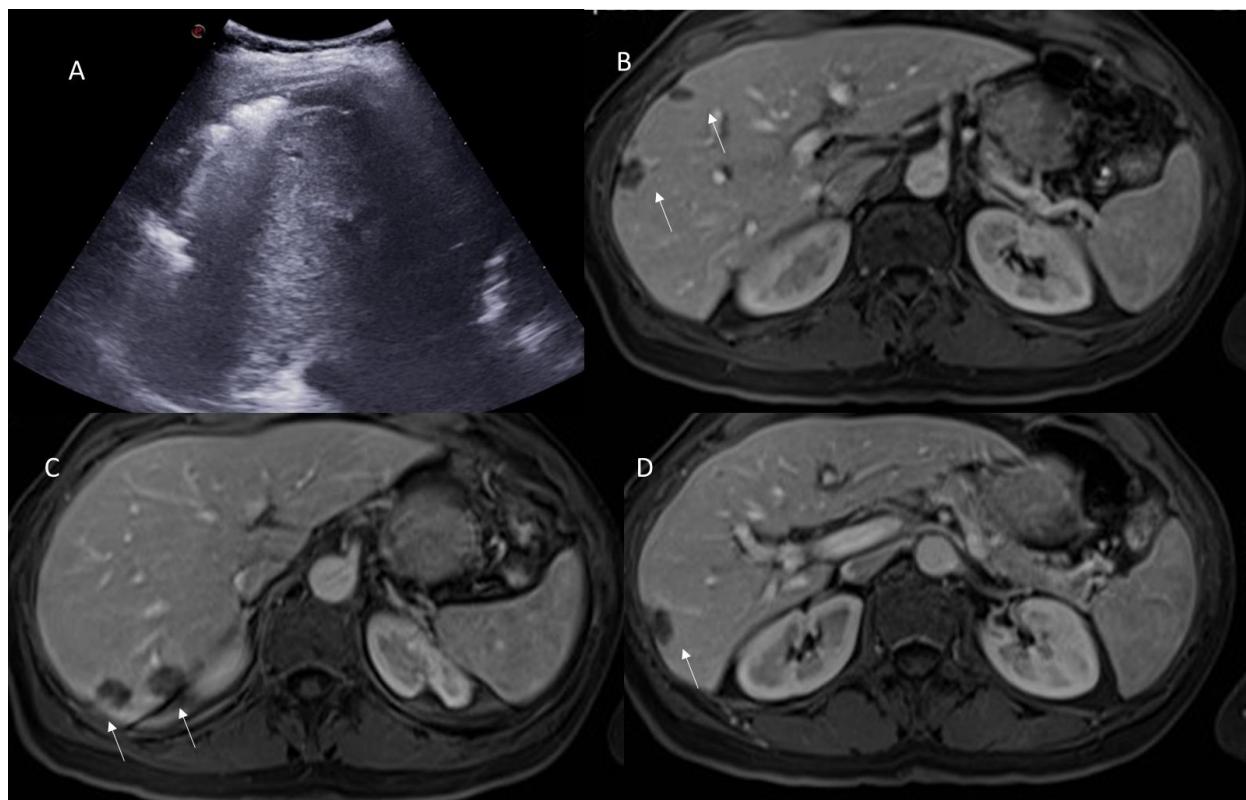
US (A) assessment and CT (B–D) assessment of Figure 3, patient. On portal phase of contrast medium evaluation, arrows ((B): V seg; (C): VII seg and (D): VI seg) show typical fluid collection due to surgical procedure.
